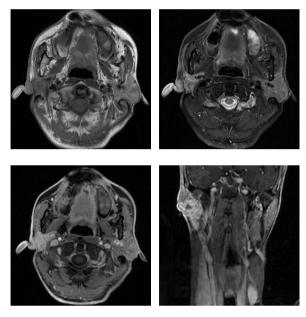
MRI of the head and neck showed that the right neck mass involved the parotid gland.
